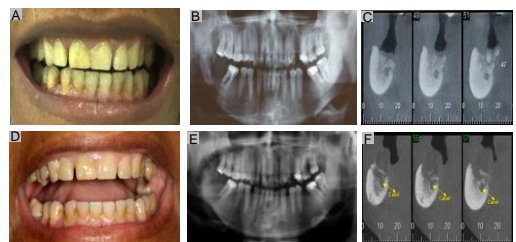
Initial consultation. A. Severe trismus. B. Extensive osteolytic lesions in the right mandibular body. C. CT scan - Transaxial reconstruction ORN evidencing a diffusely hyperdense area. Response to 12 months of treatment. D. Partial reduction of trismus. E. Pathologic fracture on the left mandibular body. F. Reduction of bone density.
